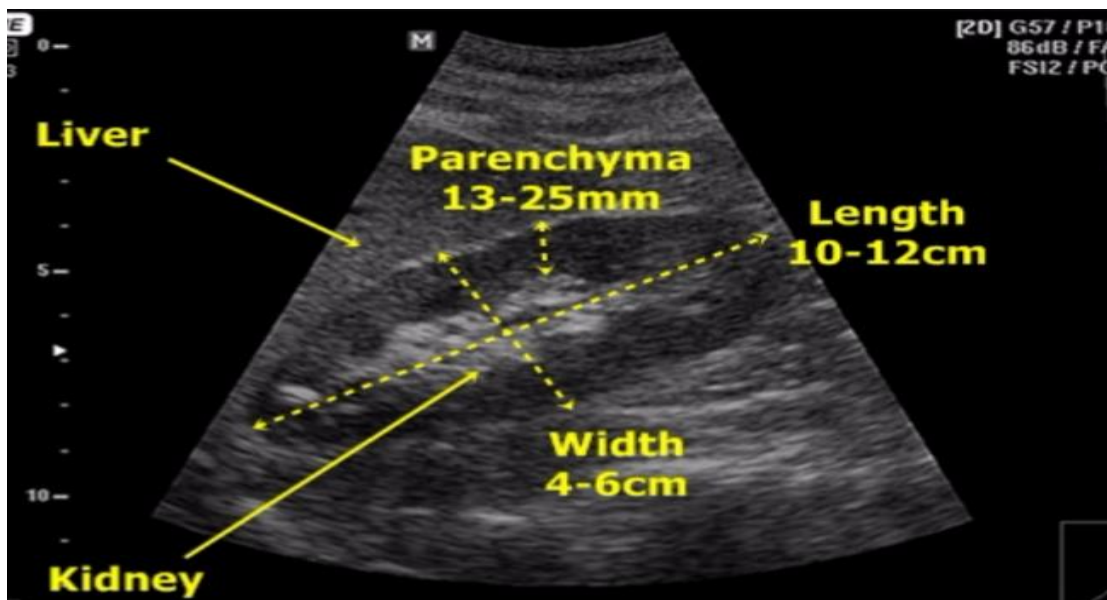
Normal Sonographic Anatomy.(Devin D,2005)
